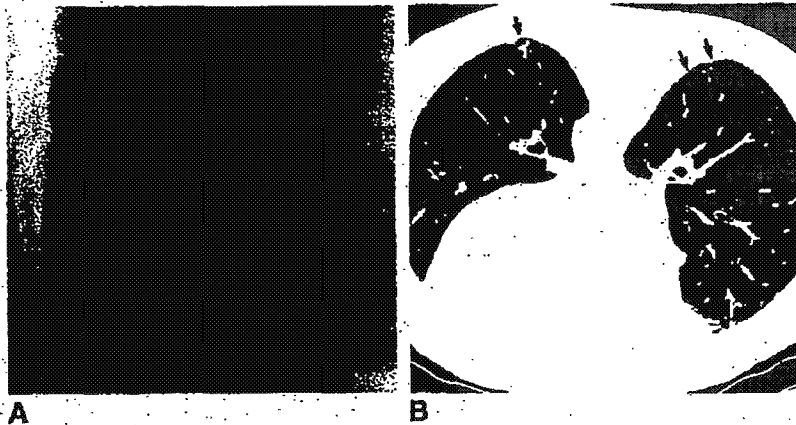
Patient with asbestosis with a normal chest radiograph and abnormal CT scan.
